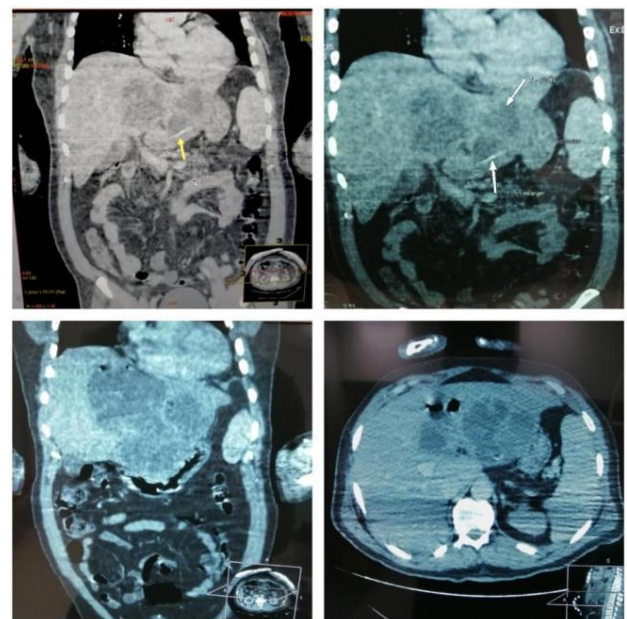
CT images showing the FB within the liver abscess
